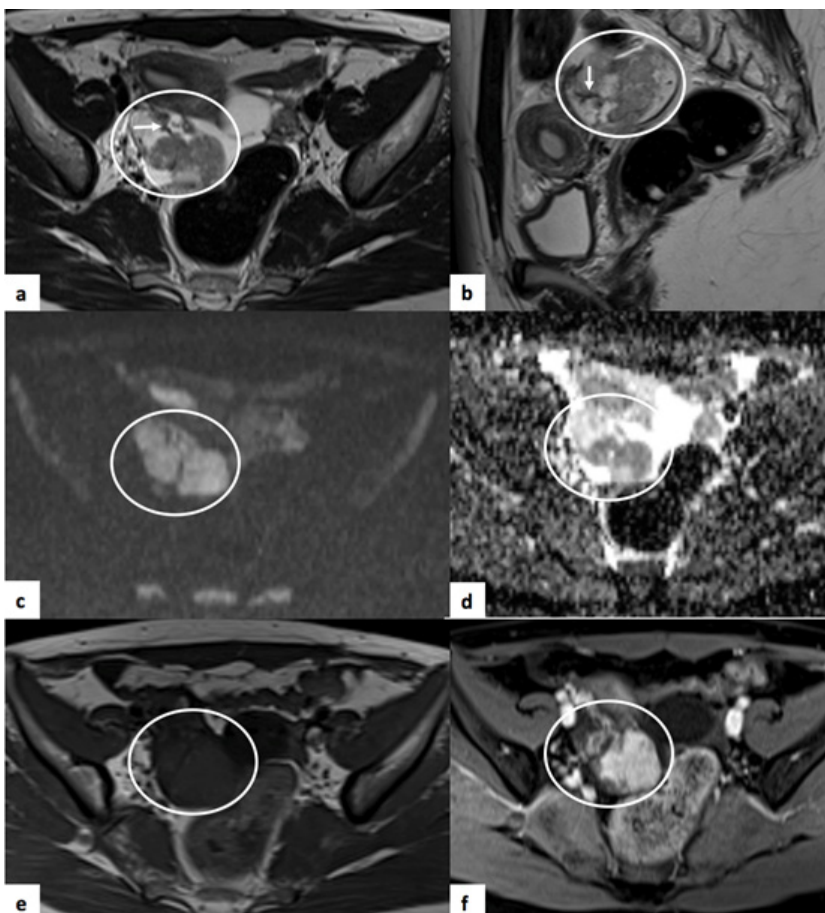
Krukenberg tumour of the right ovary. Pelvic MRI of a 30-year-old woman with a history of mucinous adenocarcinoma of the colon. (a) and (b) correspond to axial and sagittal T2 sequences, respectively, where it is possible to observe a large heterogeneous tumour (circle), of mixed nature, with multicystic component and solid regions of predominantly T2 intermediate signal. The presence of peripheral solid components with significant low signal on T2WI (arrows) is highlighted. (c) and (d) DWI ($b=1000$) and ADC map, respectively, showing restricted diffusion of the solid component. (e) T1 weighted-image; (f) T1 weighted-image with fat saturation after intravenous contrast (T1 SPAIR), where there is moderate to strong enhancement of the solid component.
